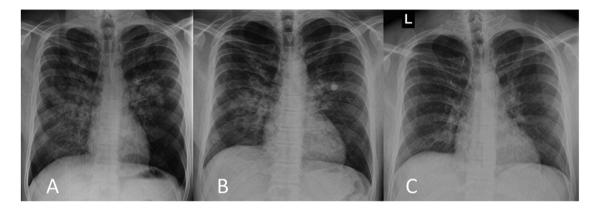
Sequential anterior-posterior chest radiographs of Patient 2, a 40-year-old male, with high-altitude pulmonary edema (HAPE) on (A) day 0, (B) day 1, and (C) day 3. Of note, the anatomical side marker is incorrectly placed on image C and the image is correctly oriented.
